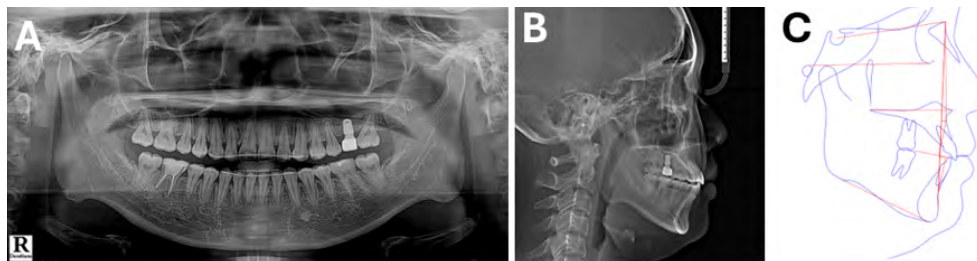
Post-treatment panoramic (A) and lateral cephalometric (B) radiographs, and tracing (C).
